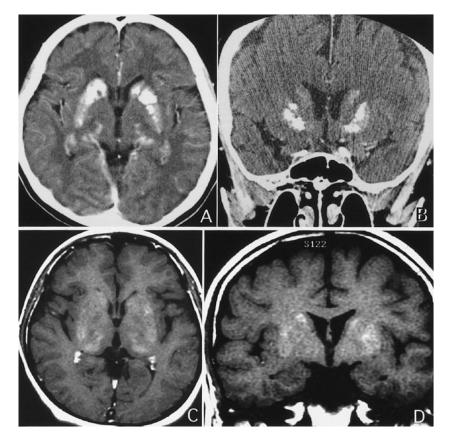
Case 1. CT scan showing calcification of basal ganglia and thalami bilaterally. (A) axial section; (B) coronal section. T1-weighted images of MR showing paradoxical high signal intensity area in basal ganglia and thalami bilaterally (C) axial section; (D) coronal section
